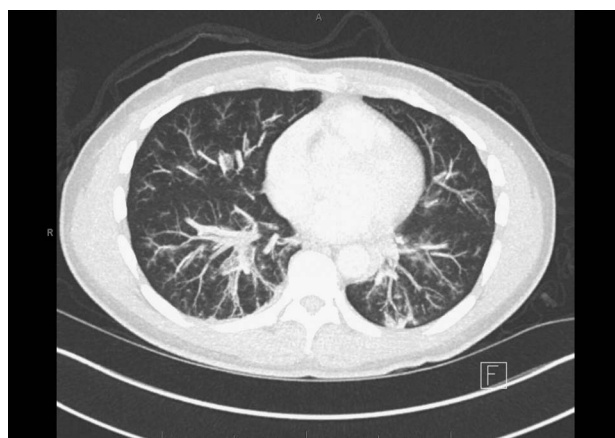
CT Chest showing groundglass opacities and tree in bud nodules.
